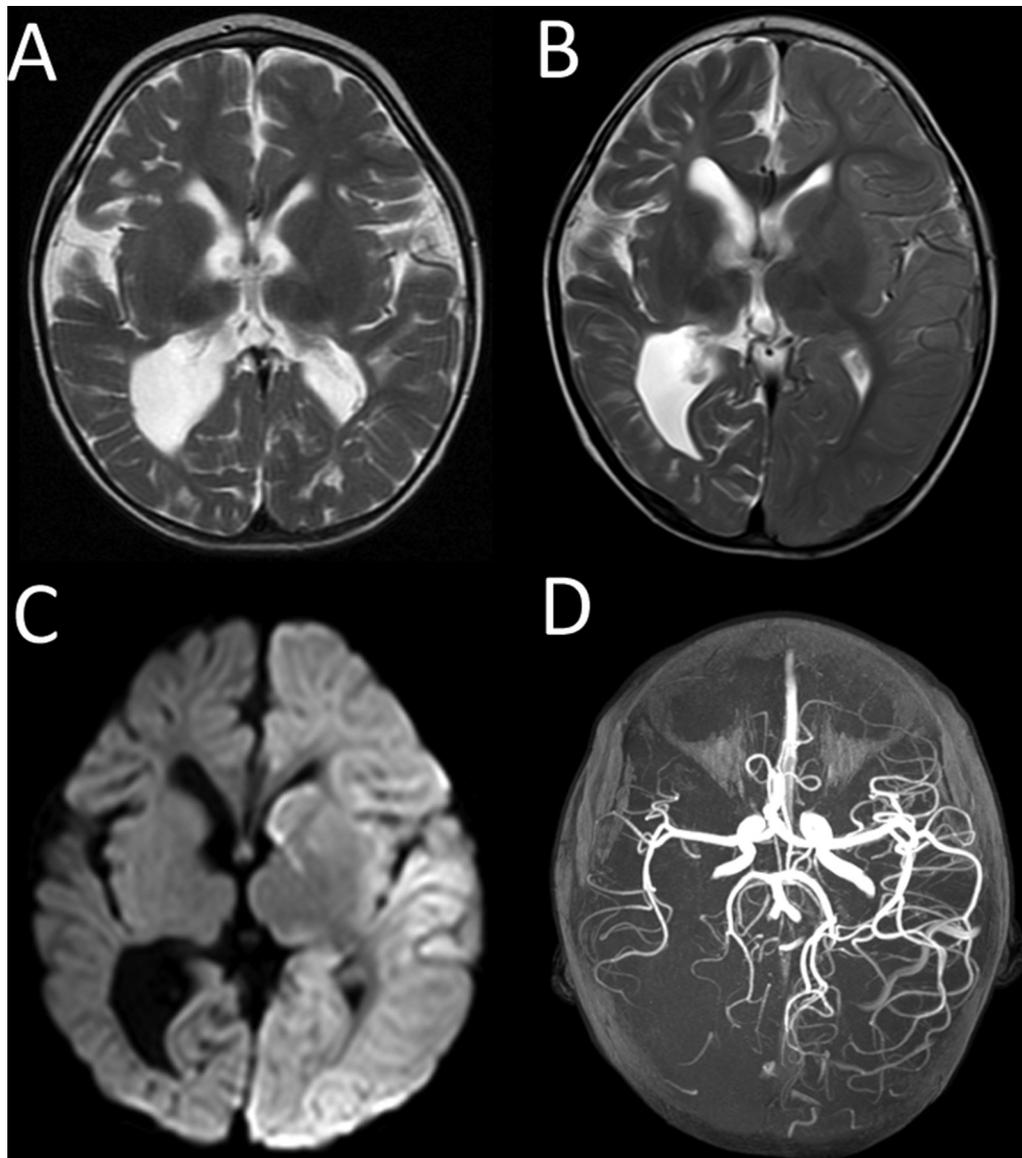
T2WI (A) from Patient 9 done eight months prior to presentation showing generalized atrophy of both cerebral hemispheres. T2WI (B) and DWI (C) of the acute-phase MRI demonstrating narrowing of the left lateral ventricle and restricted diffusion of the whole left cortex and basal ganglia. As before, the right lateral ventricle enlarged and right cerebral hemisphere atrophied. MR angiogram (D) showed dilation of the left anterior, middle, and posterior cerebral arteries. DWIs, diffusion-weighted image; MRI, magnetic resonance imaging; T2WI, T2-weighted image.
